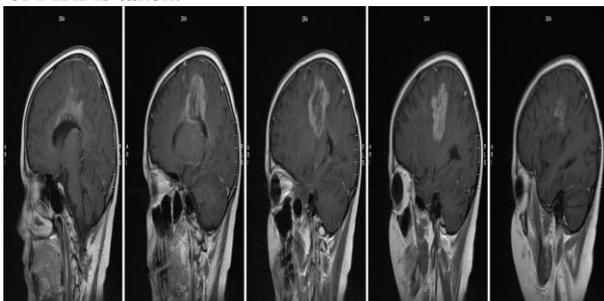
MRI Images of same patient taken at different angles in second month
